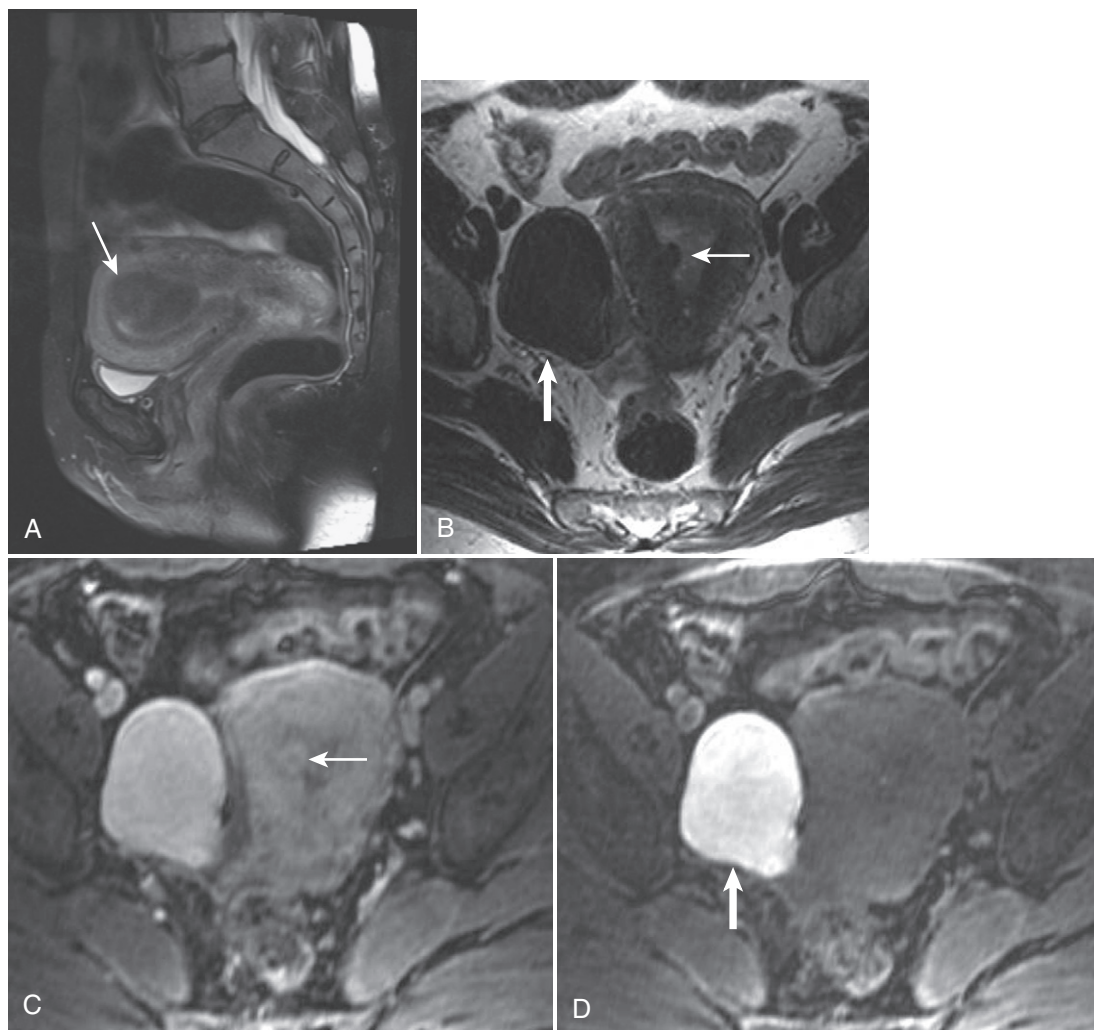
Submucosal fibroid. A, T2-weighted fat-saturated image reveals an ovoid hypointense lesion arising from the anterior fundal myometrium protruding into the endometrial cavity consistent with a submucosal fibroid (*arrow*). The axial T2-weighted (B) and enhanced T1-weighted fat-suppressed (C) images show a second small submucosal fibroid arising from the right lateral myometrium (*thin arrow* in B and C). D, A large hypointense right adnexal lesion mimics the appearance of a fibroid on the T2-weighted image (*thick arrow*)—in combination with the marked T1 hyperintensity on the T1-weighted unenhanced image (*thick arrow*)—the constellation of signal characteristics is most typical of chronic or concentrated blood products and diagnostic of an endometrioma.
